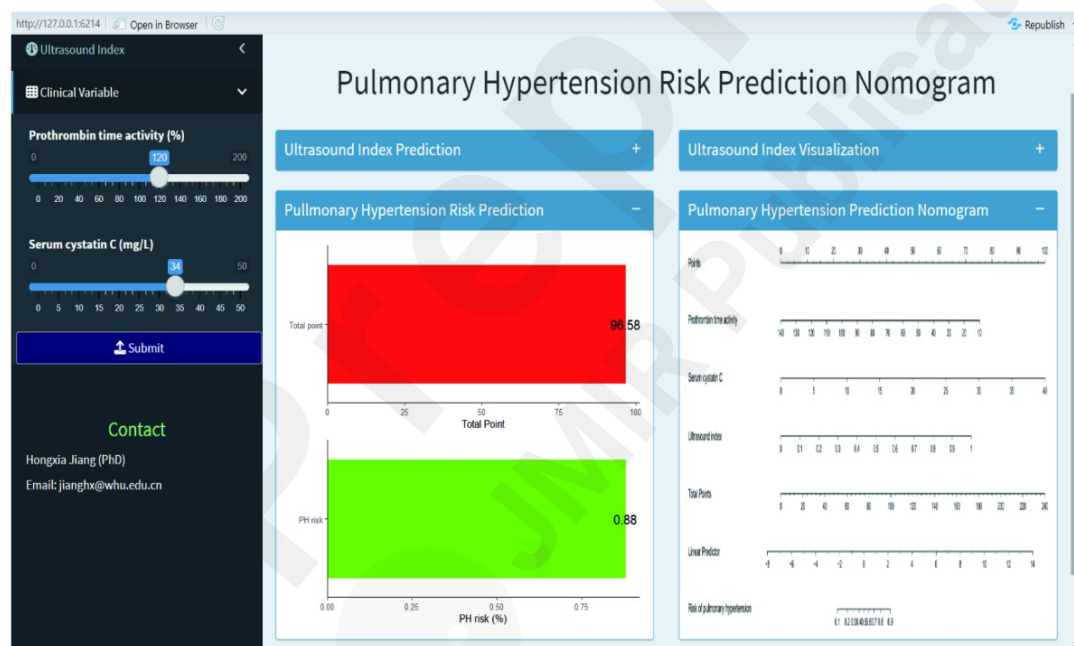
(A) Ultrasound-based pulmonary hypertension risk calculator showing index prediction and SHAP analysis explaining feature contributions to model output. The PH risk prediction nomogram uses clinical variables to calculate a total score, estimating the corresponding PH risk percentage.
